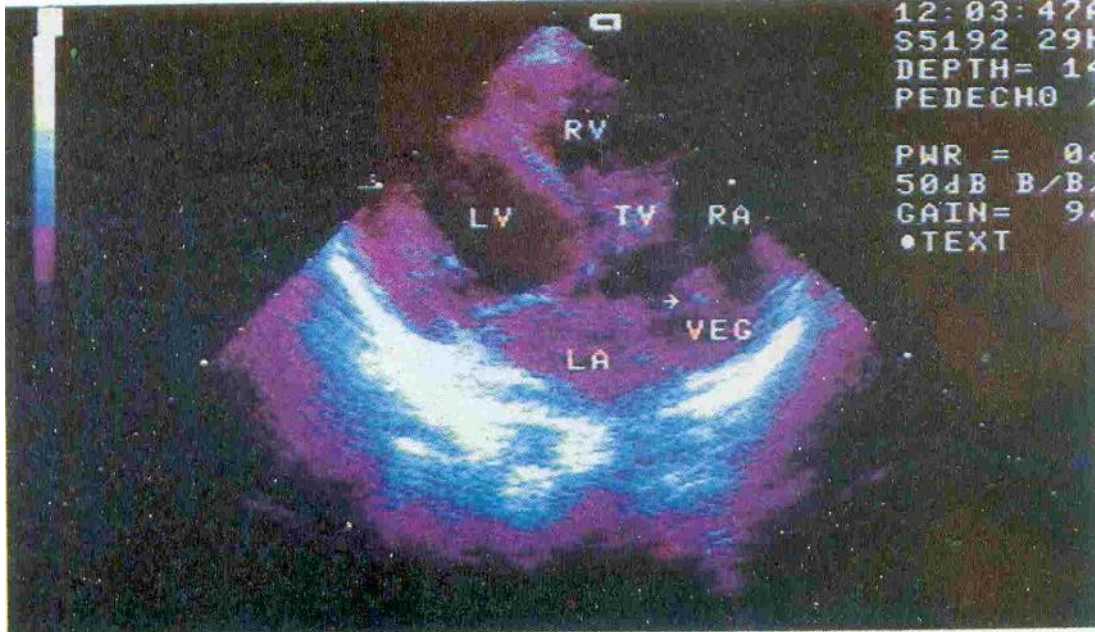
Apical 4 chamber view of echocardiographic examination showing a pedunculated vegetation (VEG) arising from the coronal leaflet of tricuspid valve (TV).
